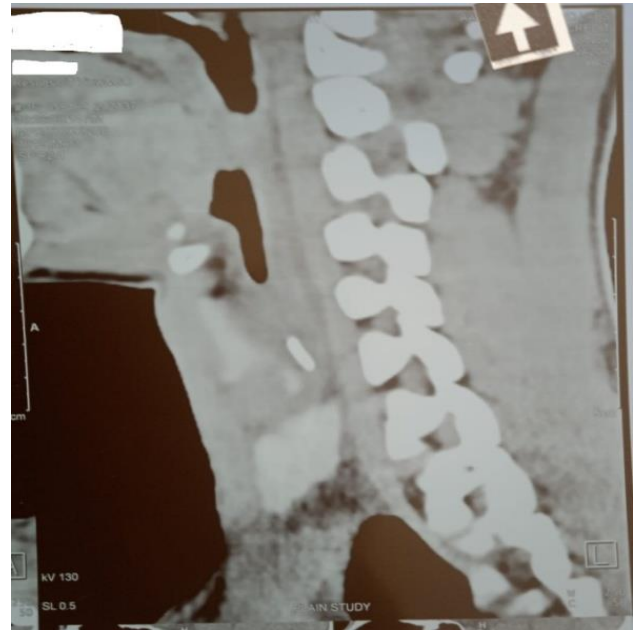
The CT shows a foreign body at the C5-C6 vertebra level.
